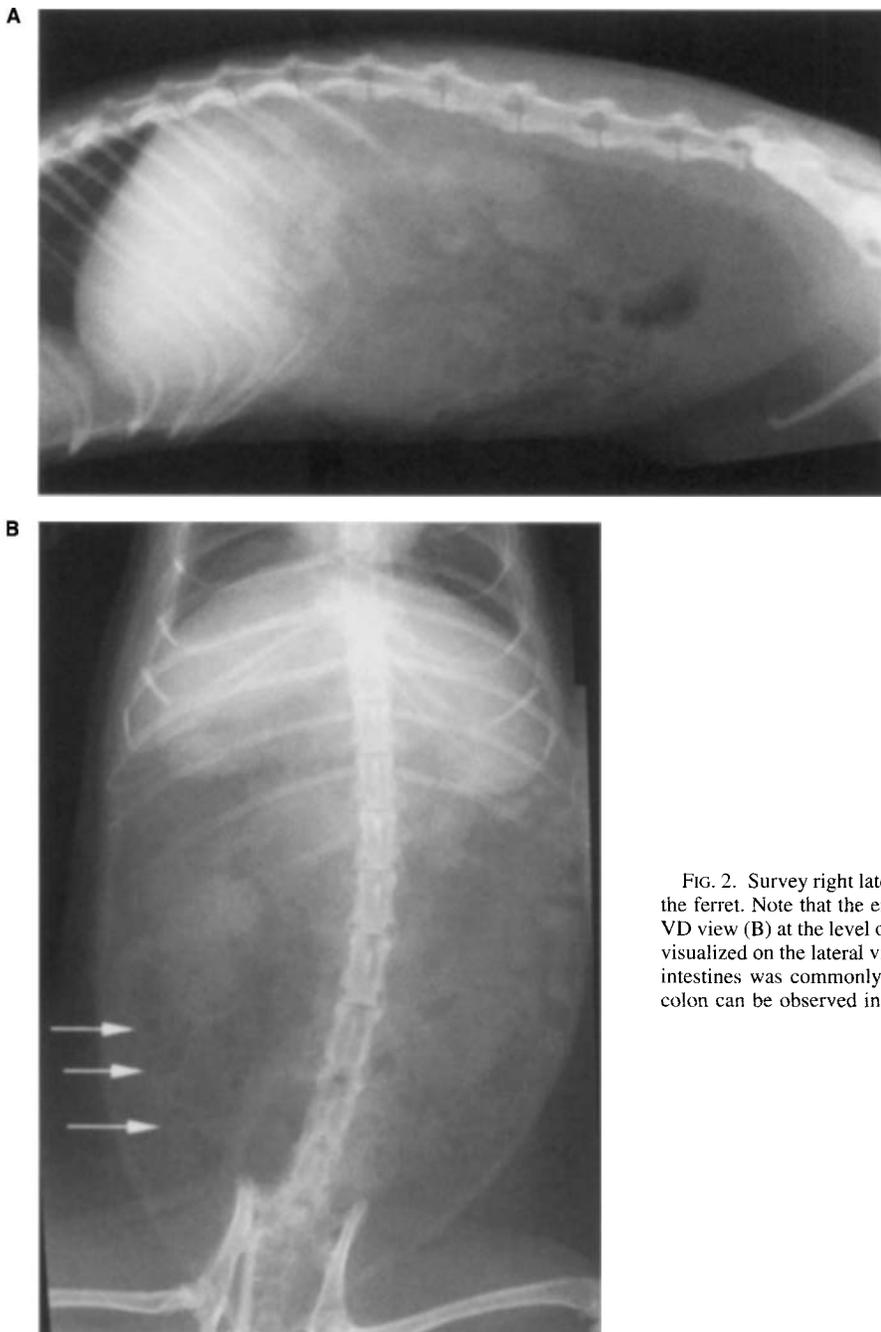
Survey right lateral (A) and ventrodorsal (B) abdominal radiographs of the ferret. Note that the empty stomach is visible in the cranial abdomen on the VD view (B) at the level of the last two intercostal spaces. The stomach is poorly visualized on the lateral view. The fragmented appearance of the gas in the small intestines was commonly seen in the normal ferret (B, arrows). The gas filled colon can be observed in the caudal abdomen on the lateral view (A).
